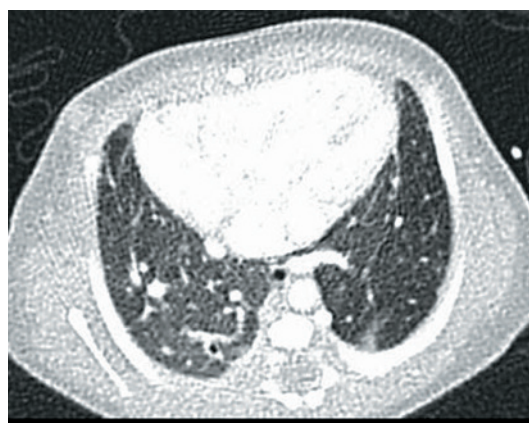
CT scans (axial and sagittal views, soft tissue window, MIP reconstruction technique). Hypoplastic left heart chambers (left ventricle and atrium are undersized, mitral valve hypoplasia) are visualized (a). Preductal coarctation of the aorta, patent ductus arteriosus and contrast enhancement of the descending aorta as a result of a ductal-dependent congenital heart defect (b)
